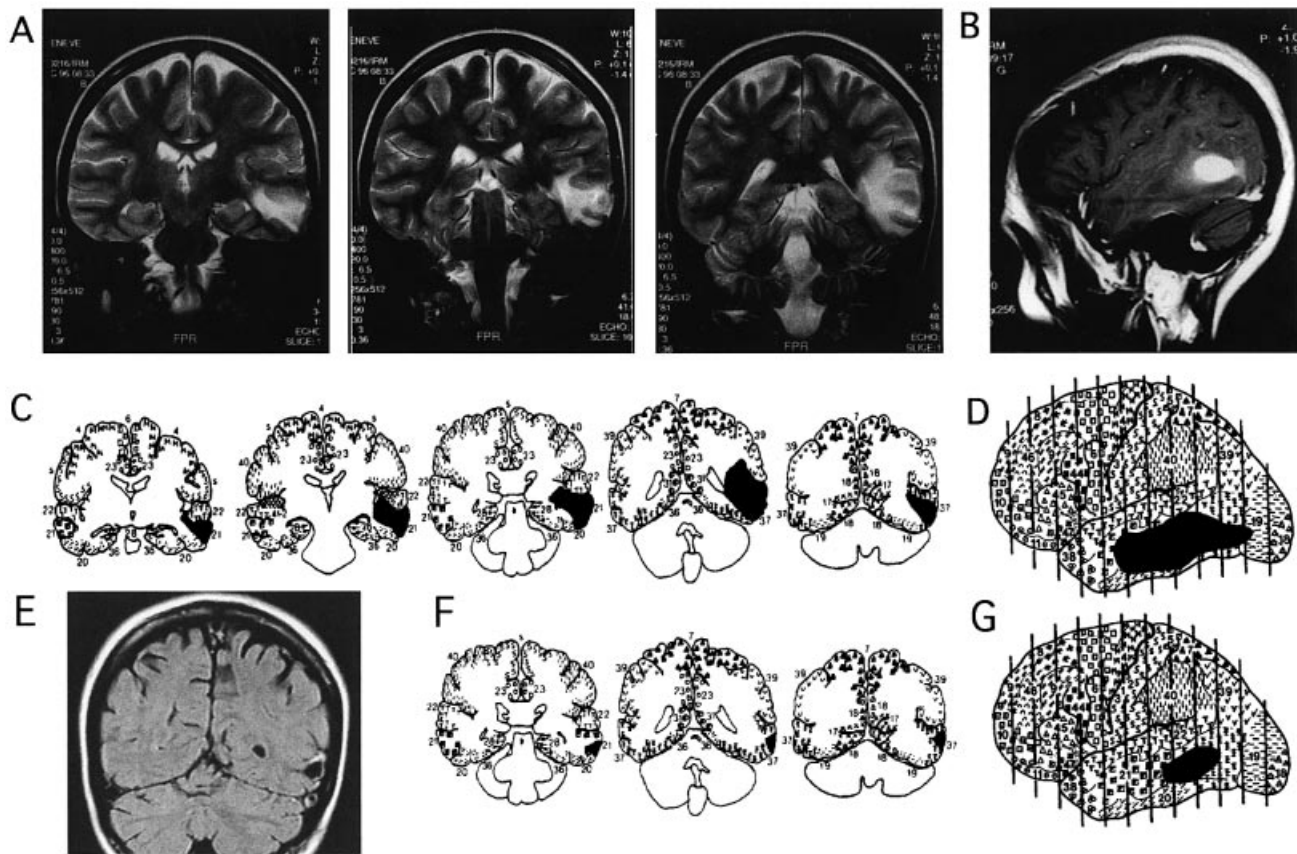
Brain MRI of the patient 10 days after stroke (A–D) and 1 year later (E–F). (A) T₂-weighted coronal and (B) T₁-weighted sagittal images showing haemorrhagic infarction in the posterior middle and inferior temporal gyri of the left hemisphere, close to the temporo-occipital junction, and in the paraventricular occipital white matter. (C, D) Corresponding anatomical templates using the method of Damasio and Damasio (1989). The acute lesion was centred on Brodmann areas 37, 21 and 20. (E) In the chronic stage, T₁-weighted coronal images show a focal cystic lesion in the same area. (F) Corresponding anatomical templates, showing that persistent damage is centred on the middle temporal gyrus.
